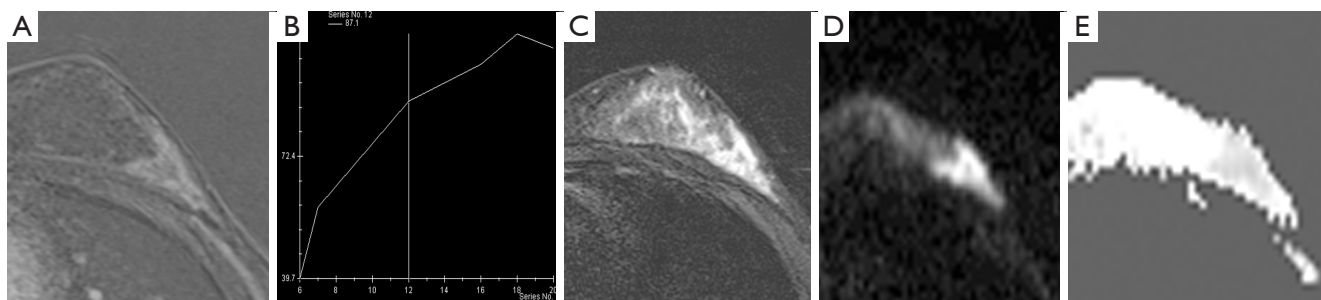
A 18-year-old woman presented with NME in the left breast on MRI which was classified as BI-RADS 4 category. (A,B) The lesion displayed segmental distribution, heterogeneous internal enhancement, circumscribed margin and persistent kinetics. (C,D) The lesion showed high signal intensity on both T2WI and DWI. (E) ADC value was $1.12 \times 10^{-3} \text{ mm}^2/\text{s}$. The lesion was classified as benign by Kaiser score and as malignant by the three mpMRI-based decision rules. Pathology revealed adenosis. NME, non-mass enhancement; MRI, magnetic resonance imaging; BI-RADS, breast imaging reporting and data system; T2WI, T2-weighted imaging; DWI, diffusion-weighted imaging; ADC, apparent diffusion coefficient; mpMRI, multiparametric magnetic resonance imaging.
